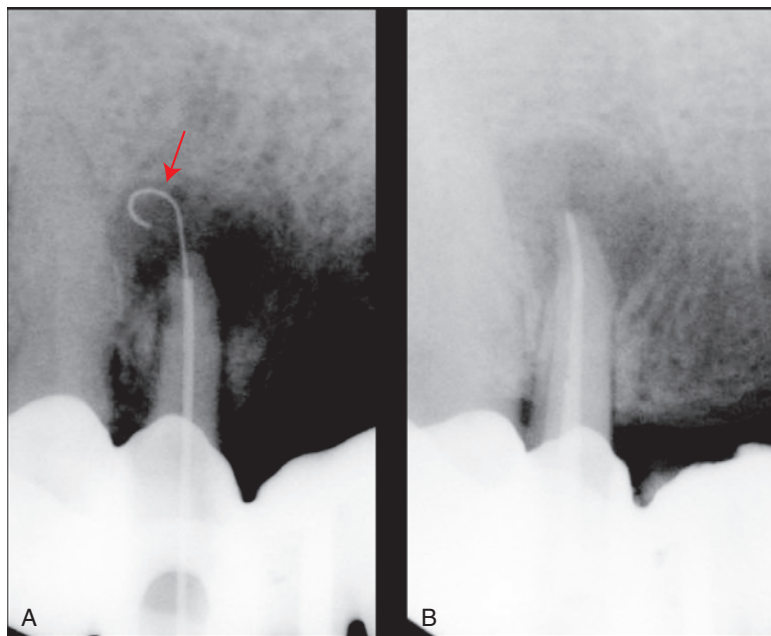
The Apexum NiTi Ablator in a periapical lesion. A, The Apexum NiTi Ablator fully extruded from its sheath and into the periapical lesion. B, Root canal filling performed immediately after the Apexum procedure. Metzger Z et al. J Endod 2009;35(2):155. Reproduced with permission.
